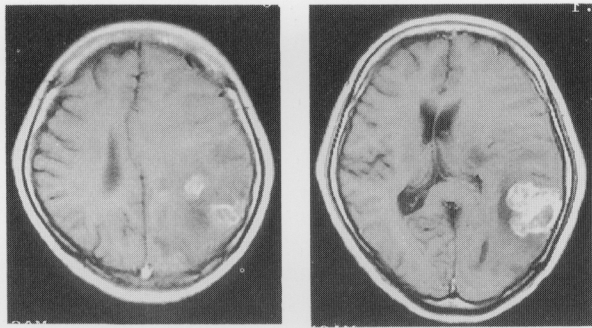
MRI on enhanced T1 weighted images revealed irregular ring-enhanced tumor in the left temporo-parietal lobe.
